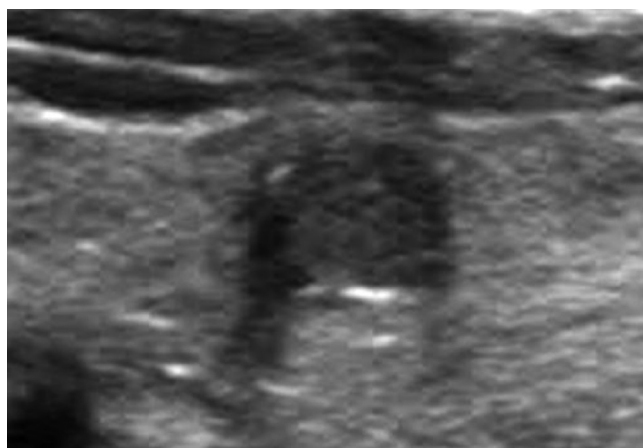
A 50-year-old woman with a BRAF V600E mutation positive papillary thyroid carcinoma. The nodule has marked hypoechoic internal echogenicity and peripheral rim calcification, as well as a spiculated margin, particularly at the right aspect, indicating malignant ultrasonographic features.
